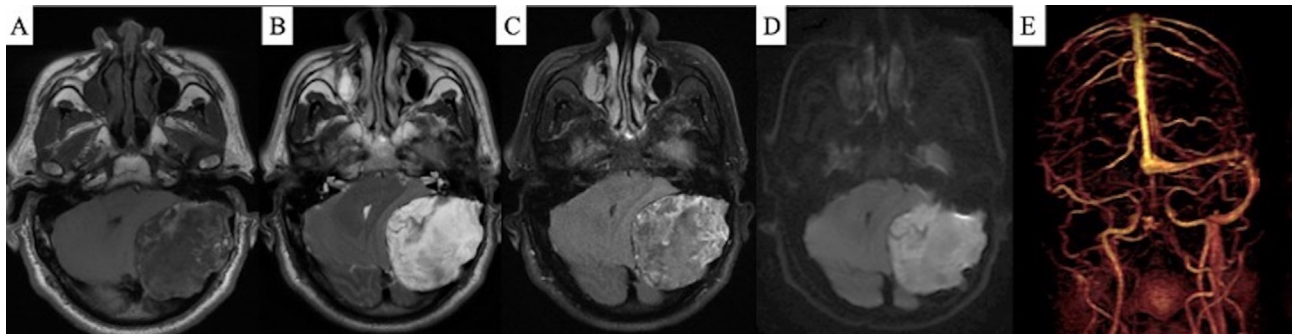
Brain MRI scan in its different sequences at the posterior fossa level. Presence of left temporal extra-axial tumor and extension to the posterior fossa.
